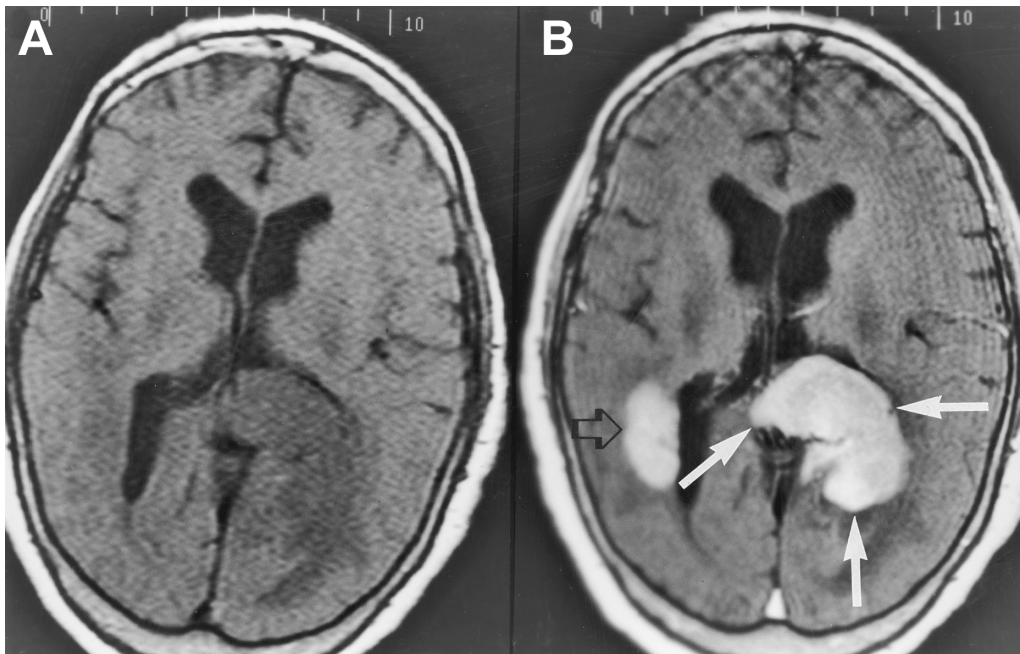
Primary lymphoma of the brain. Non-contrast (A) and post-contrast (B) MRI scans at the level of the lateral ventricles. An enhancing mass involving the splenium of the corpus callosum (arrows) and right paraventricular region (open arrow) is shown. The location of the mass and the homogeneous enhancement of tumor are commonly seen in lymphoma.
